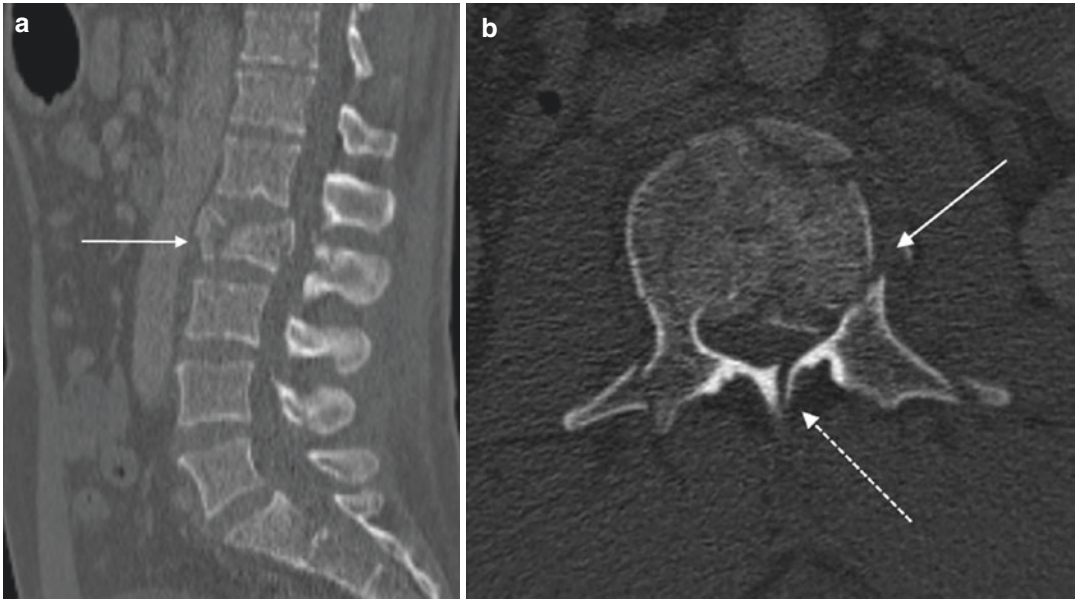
Sagittal CT image (a) shows a burst fracture through the L2 vertebral body with the involvement of the posterior cortex (white arrow) and a left lamina fracture (white dotted arrow) suggesting the involvement of the posterior tension band/PLC making this an AO subtype B2 injury (b) shows extension of the fracture to the left pedicle
